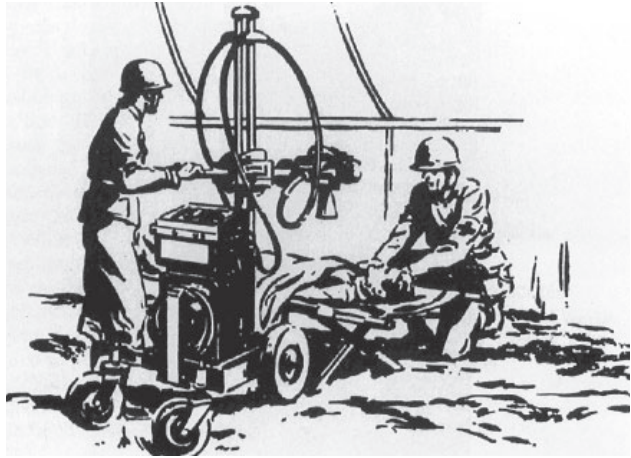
A portable field x-ray unit in action in World War II. The unit shown was developed by the Picker Corporation, which became the sole supplier of the US Army field x-ray unit during World War II.
